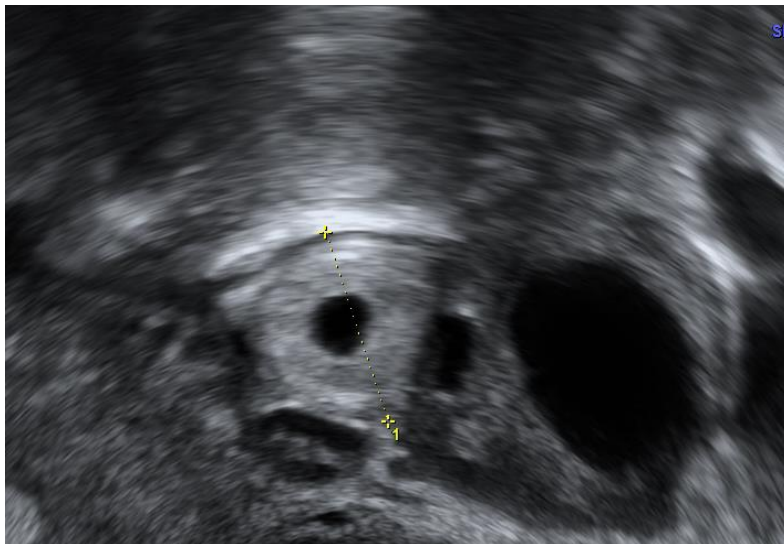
Transvaginal ultrasound images showing different morphological types of ectopic pregnancy in the fallopian tube. (a) Solid inhomogeneous mass (blob sign). (b) Empty gestational sac with a hyperechoic ring around (bagel sign).
